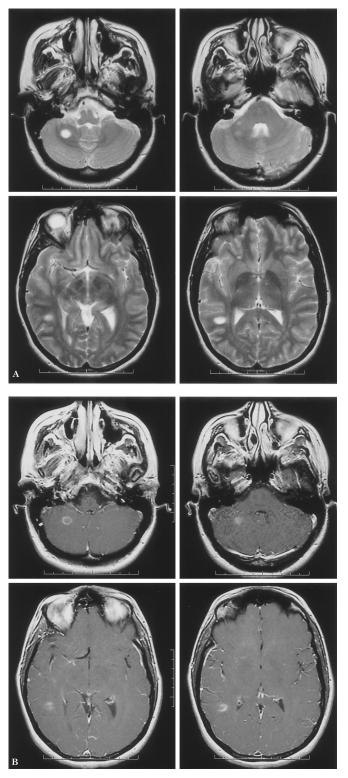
MRI scans obtained 2 months after presentation. There were no new complaints and the neurologic examination was normal. (A) Axial T2-weighted images reveal two new large areas of hyperintensity. (B) Axial T1weighted images obtained after the administration of gadolinium demonstrates enhancement of these same areas consistent with active inflammation.
